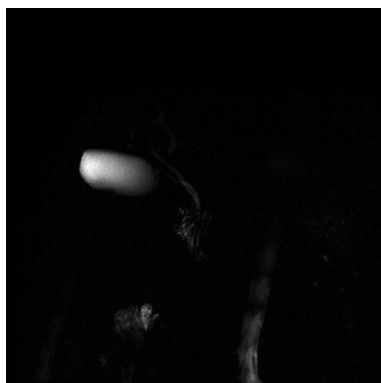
Magnetic resonance imaging, performed at the 12th week of follow up, showed a resolution of the radiological picture, with persistence of minimal dilation of the left biliary branch.
